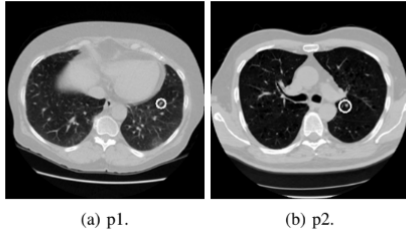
Nodules predicted by the nodule detector on 2D slices of CT scan (Encircled by a white circle).
